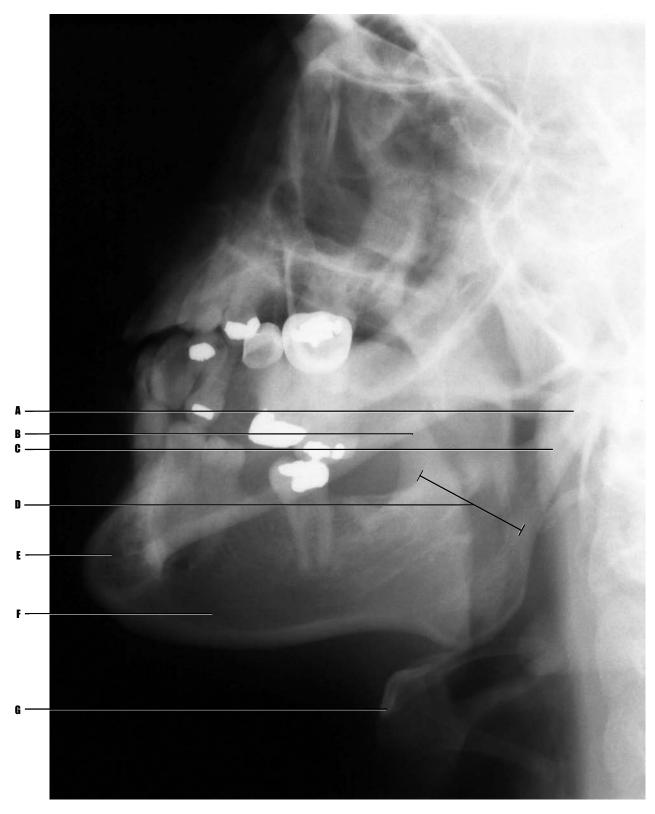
(above) Adult patient, plain film radiograph of oblique mandible.
